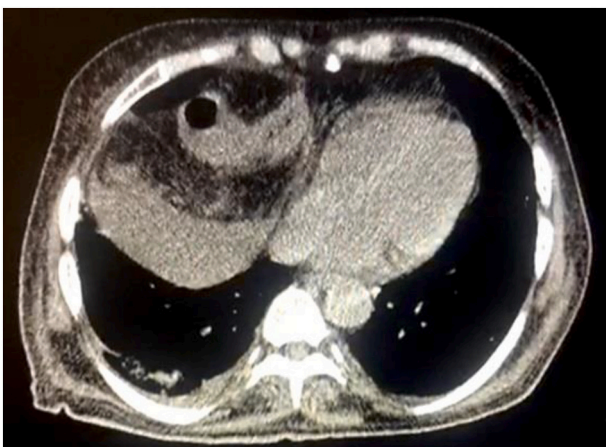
CT scan showing a Morgagni Hernia.
